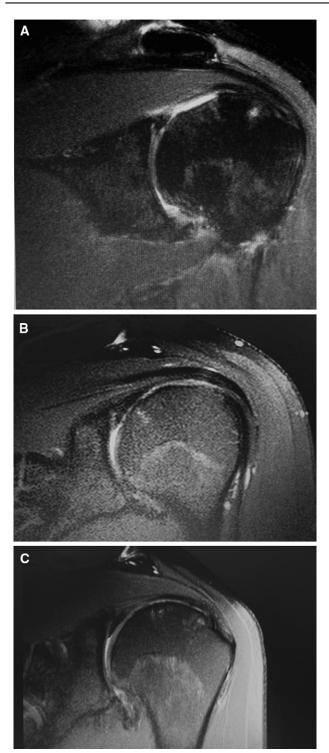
MRI assessment of patient 1 (fat-suppressed PDw TSE coronal sequences): preoperative humeral cartilage lesion (A) repair tissue 30 months postoperatively (B) and repair tissue with residual minimal subchondral edema 71 months postoperatively (C).
